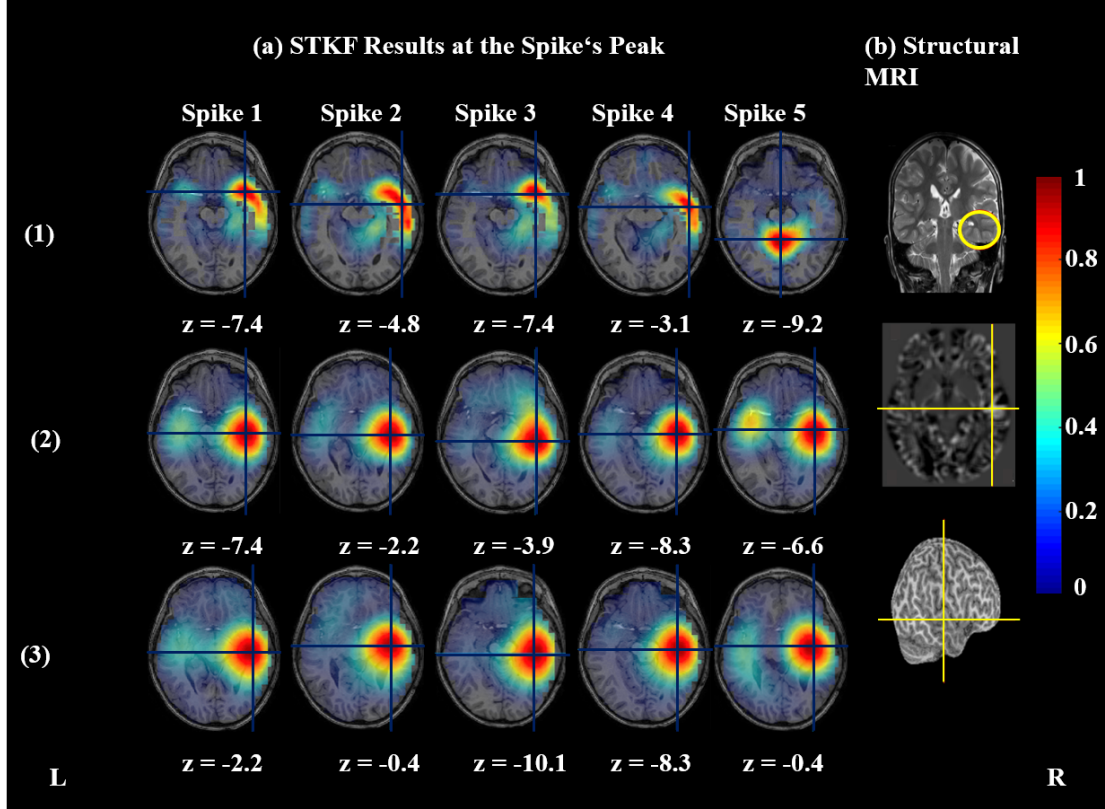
(a) Results of EEG source imaging via STKF of 5 non-averaged spikes from the EEG recordings of Patient 1. STKF results using a gray-matter 3D grid and the classical Laplacian matrix are depicted in (1). Results using a full-brain 3D grid and the classical Laplacian matrix are shown in (2). For the results shown in (3), a full-brain grid and the modified Laplacian matrix were used. From left to right the results of Spikes 1-5 are shown in columns 1-5, respectively. The results are visualized as axial MRI slices at each spike's onset, which is defined as 50% of the spike's rise time, and the cursor is placed at the maximum of the estimated current density. Additionally the z-coordinates of the axial slices are shown in Montreal Neurological Institute (MNI) coordinates. In (b) The location and the extent of the FCD on a coronal slice from the patient's preoperative T2-weighted MRI is shown and marked with a yellow circle (top). Additionally in (b), the centers of the yellow cursor mark the detected FCD on an axial slice after morphometric Huppertz MRI analysis [HGF<sup>+</sup>05] (middle) and the FCD on the brain's cortical surface after morphometric Huppertz MRI analysis [HGF<sup>+</sup>05] (bottom). The source imaging results were visualized using the Fieldtrip software [OFMS11]. The figure was adapted from the figures published by the author in [HHJ<sup>+</sup>15]
